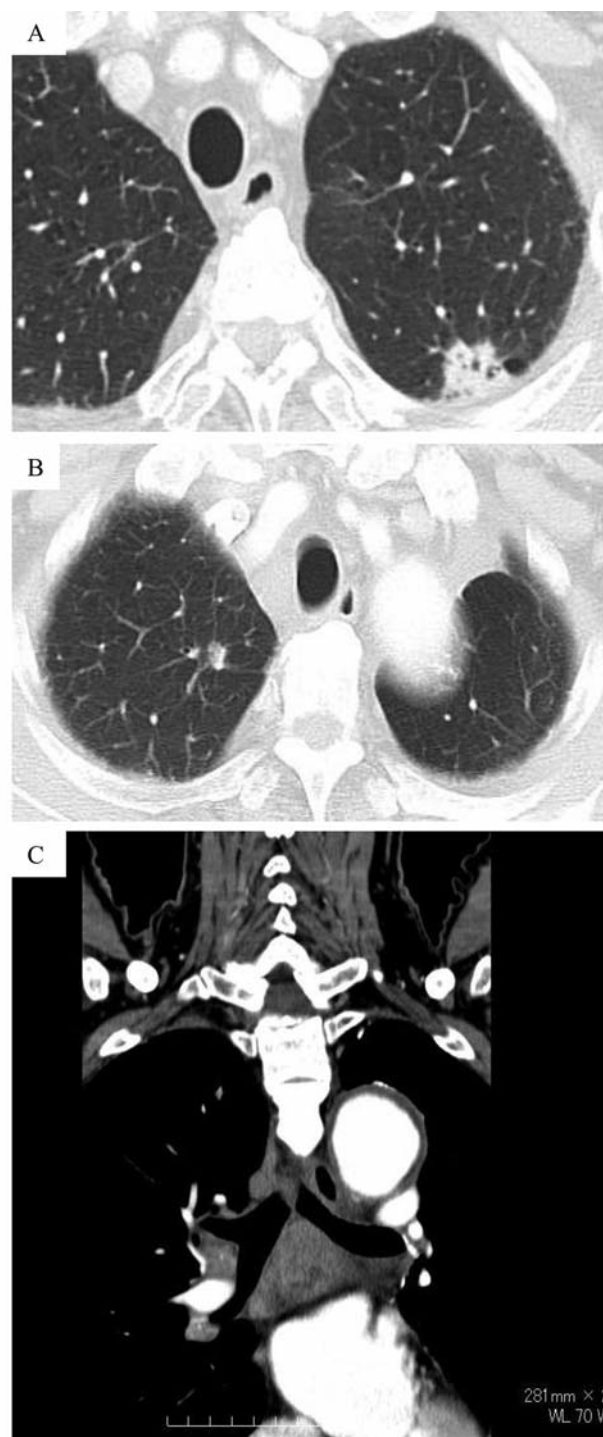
Case 2: A: Recurrent case: Chest computed tomography (CT) showing a tumor in the upper left lobe, as in Case 1. The pathological findings showed squamous cell carcinoma. The pathological stage was judged to be T1bN0M0 stage IA. B and C: Pulmonary metastasis (B) and mediastinal lymph node metastases (C) were detected 29 months after complete resection. The pathological findings confirmed lymph node metastasis on mediastinoscopy. The disease showed rapid progression and no longer responded to chemoradiotherapy. As a result, the patient died due to multiple bone metastases and left adrenal metastasis.
